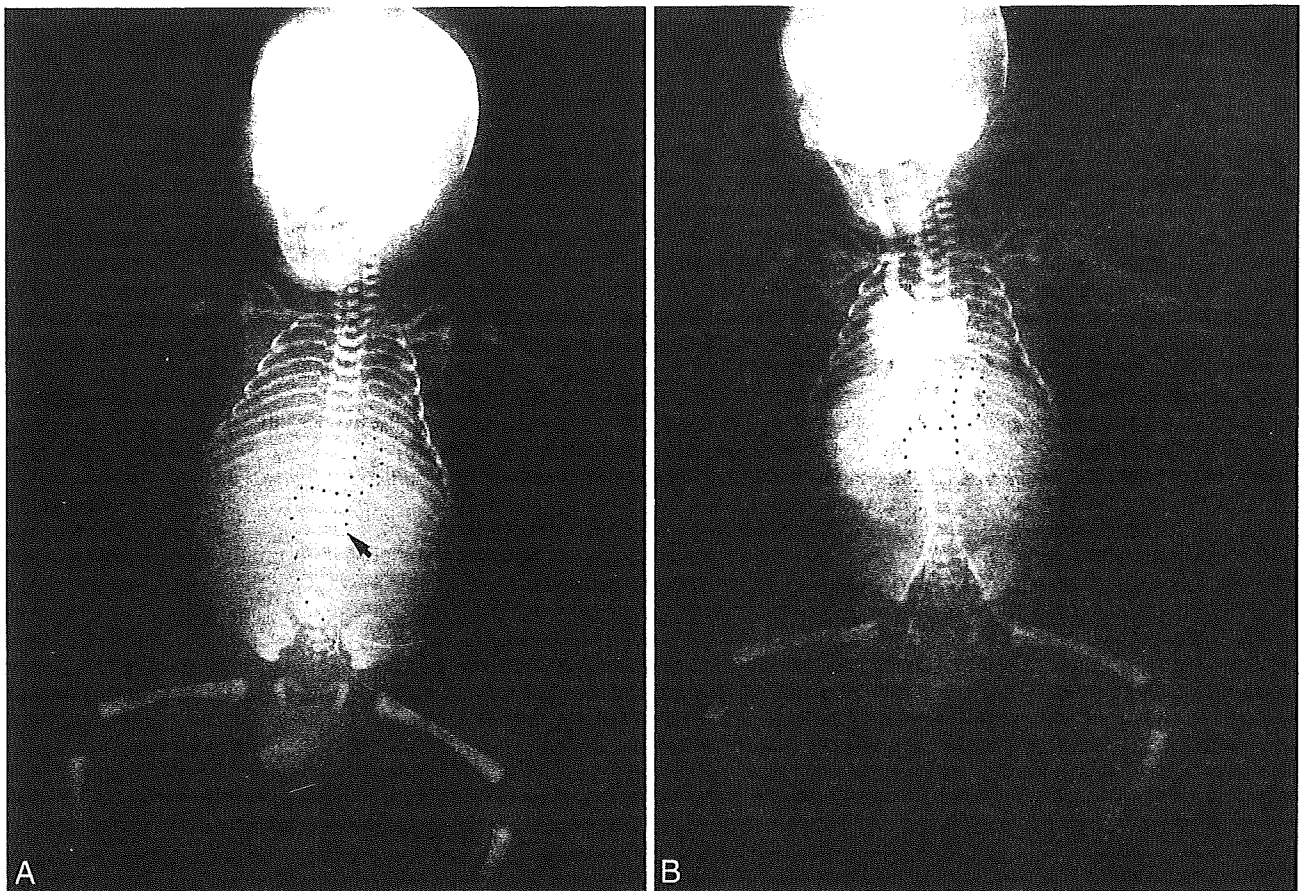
Total body X-ray examination. A. The umbilical vein catheter ran an unusual course (dots). B. Left renal vein and inferior vena cava (IVC) were detected after postmortem injection of a radiopaque dye from the umbilical vein catheter (dots).
